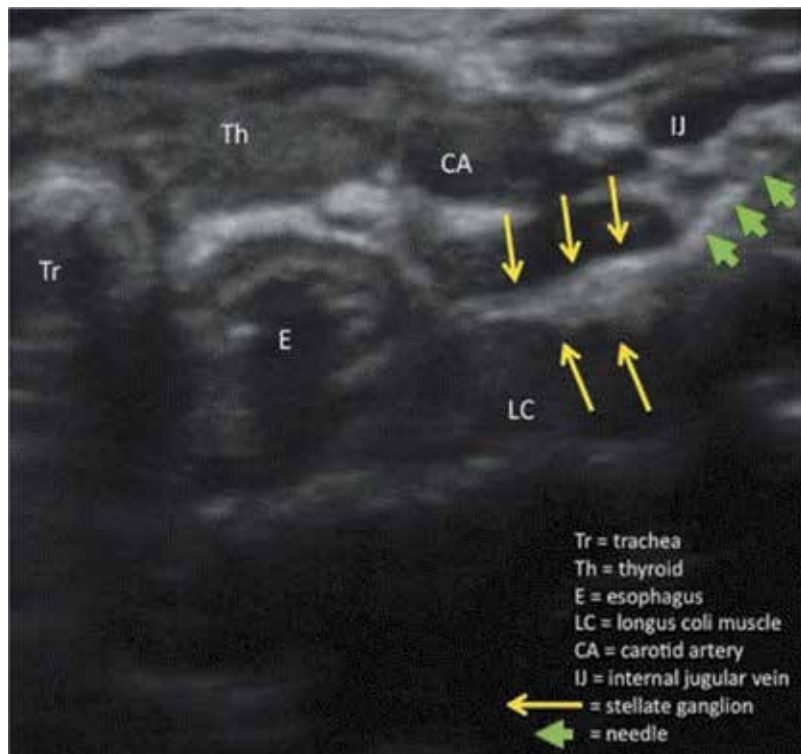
Ultrasound of left stellate ganglion (indicated by long yellow arrows) and related anatomy are shown. Note proximity to the carotid artery (CA) and the internal jugular (IJ) vein. The short green arrows indicate the block needle. Courtesy of the New York Society of Regional Anesthesiology (NYSORA).
